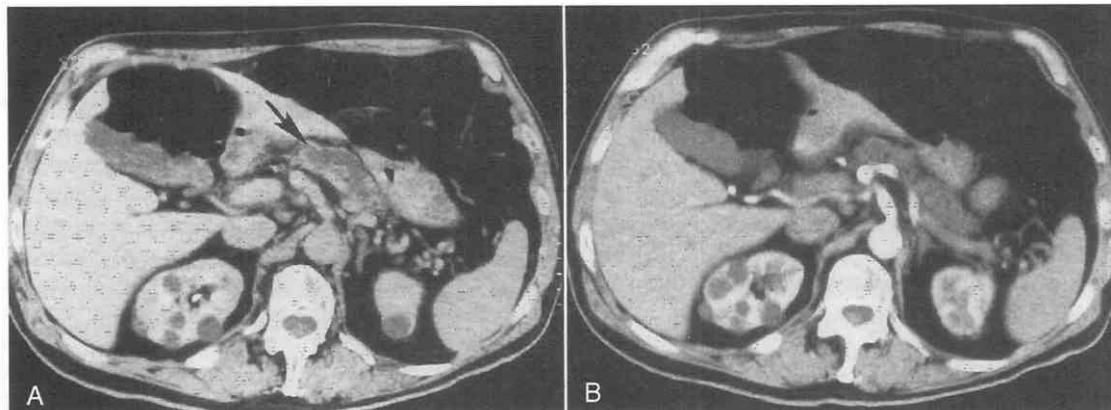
A, Patient with adenocarcinoma, before treatment. CT scan shows an enlarged pancreatic duct (arrow) that has a duct-to-gland diameter ratio less than 0.5. B, After chemotherapy, the pancreatic duct returned to normal size.
